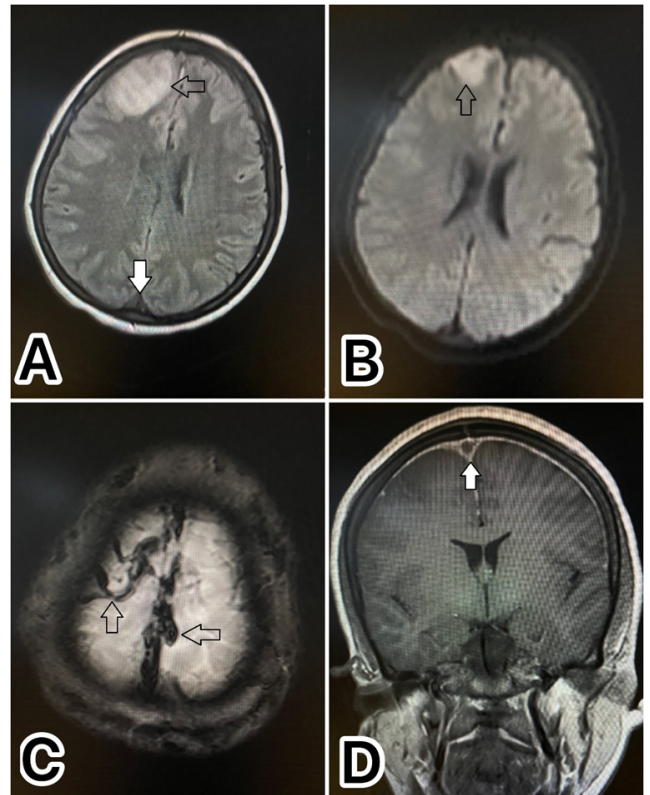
A): Showing absence of flow void in the superior sagittal sinus (White arrow) and a hyperintense lesion in the right frontal lobe (Black arrow) that shows restriction on DWI axial image; B): Axial image; C): Shows blooming in the superior sagittal sinus and right cortical veins (Black arrows) on GRE sequence. Post contrast coronal image; D): Shows a triangular filling defect outlined by contrast (empty delta sign) within the superior sagittal sinus. Findings are consistent with cerebral venous thrombosis of superior sagittal sinus and right cortical veins with venous infarct involving right frontal lobe
